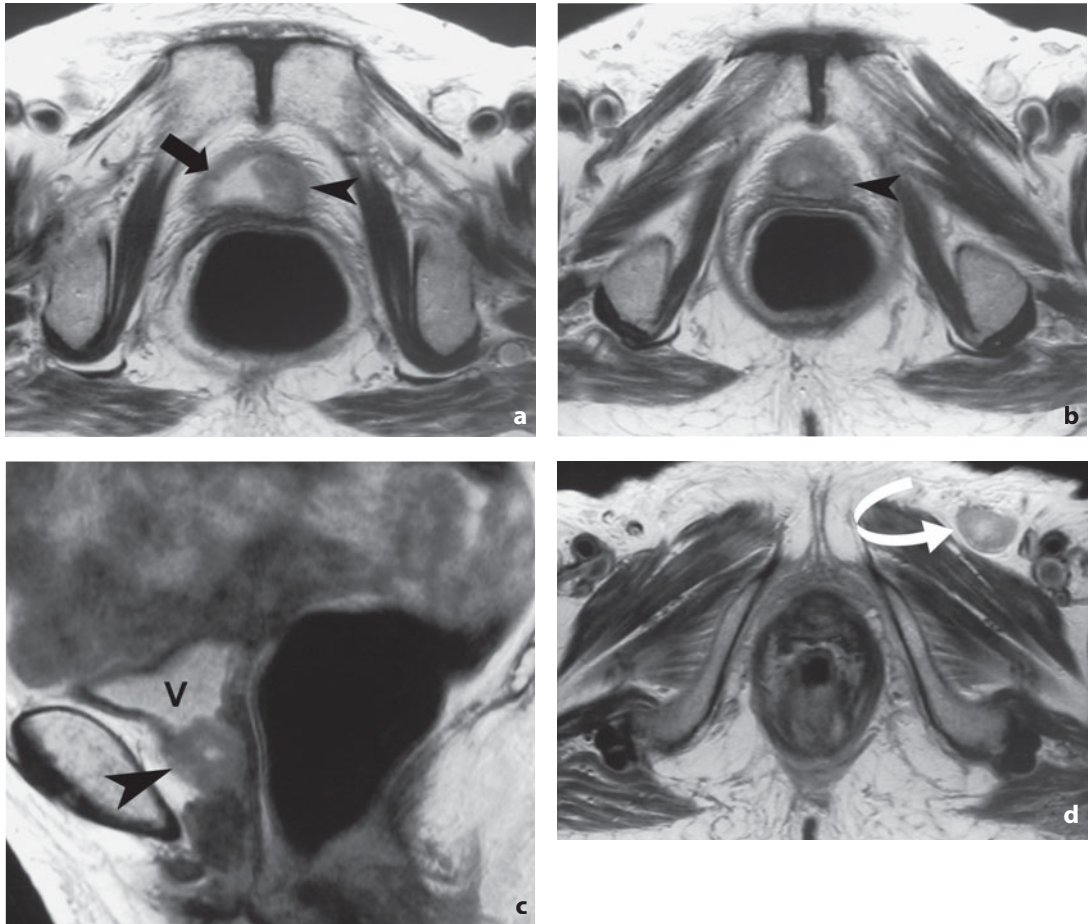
Magnetic resonance. Pelvic recurrence of vulvar cancer. The axial T2-weighted images (a,b) show a solid mass (*arrowhead*) invading the fundus and neck of the bladder (*arrow*). The finding is confirmed in the sagittal T2-weighted image (c). d Contrast-enhanced axial image acquired more caudally than the previous images shows left inguinal metastatic lymph nodes (*curved arrow*)
